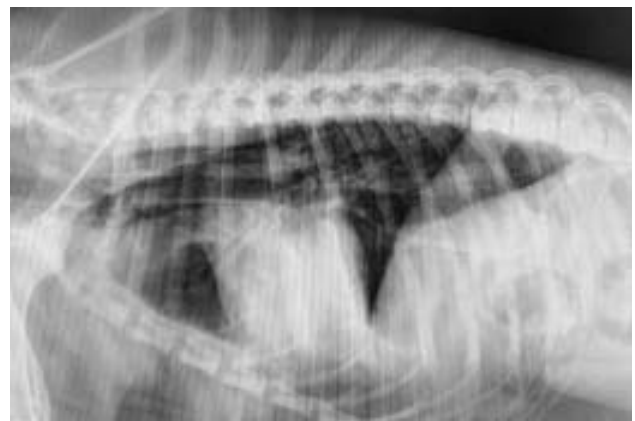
Postoperative radiograph of the right lateral thorax on day 5, post 2nd thoracotomy.
